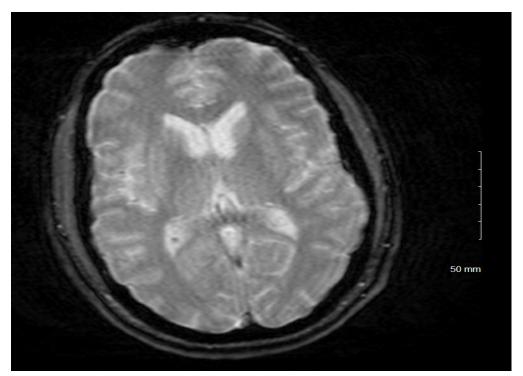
Brain MRI Gradient ECHO: Magnetic resonance image with normal signal suggesting low likelihood for subarachnoid hemorrhage.
